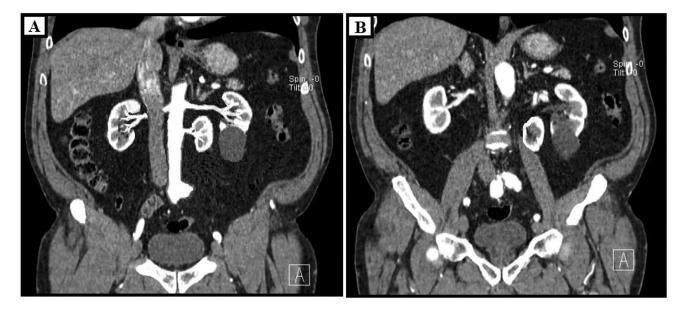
Coronal view computed tomography (CT) images in arterial phase of the kidneys demonstrates a native right kidney, as well as not fused with left native kidney the separate ectopic supernumerary left kidney which have own blood supply from aorta (A, B).
